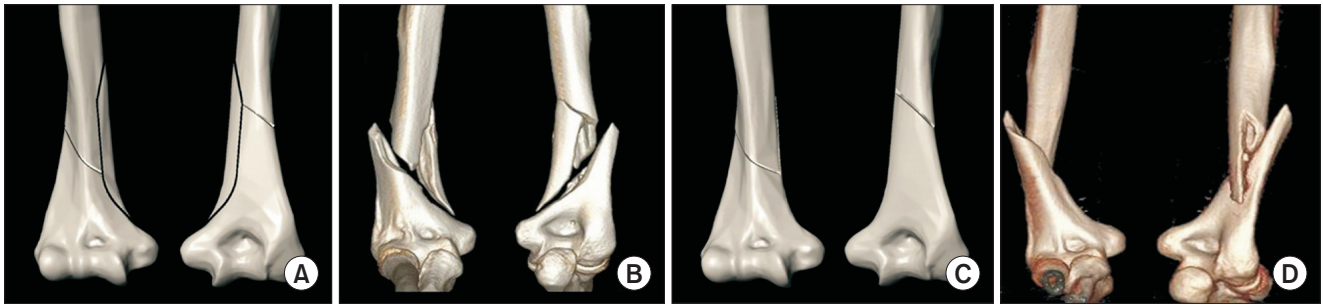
Three-dimensional (3D) modeling of fracture models. (A) Three-part spiral wedge fracture (AO 12-B1) model in Solidworks. (B) Three-part spiral wedge fracture (AO 12-B1) model in patient's 3D computed tomography. (C) Two-part spiral fracture (AO 12-A1) model in Solidworks. (D) Two-part spiral fracture (AO 12-A1) model in patient's 3D computed tomography.
